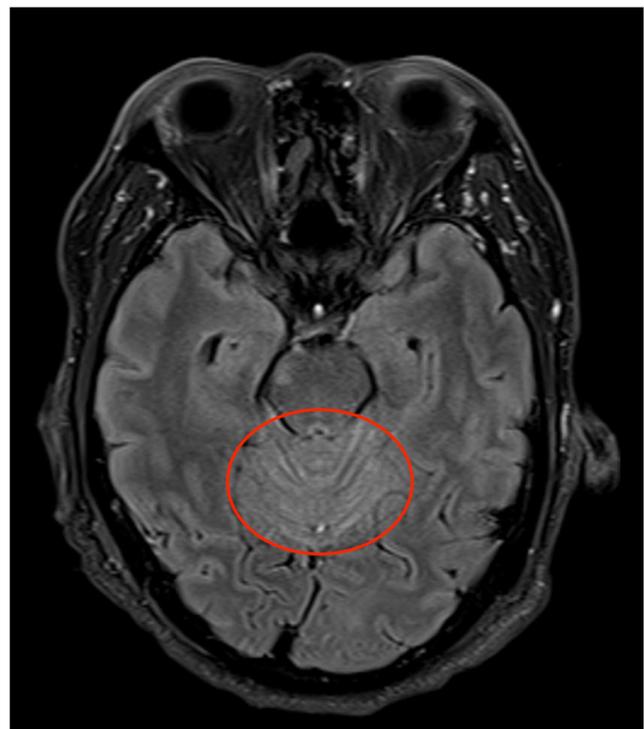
Leptomeningeal enhancement. Axial contrast enhanced fluid-attenuated inversion recovery (FLAIR) prepared T2-weighted imaging reveals linear high signal intensity over the surface of the cerebellum (red circle) not present on the pre-contrast FLAIR (not shown) compatible with leptomeningeal enhancement
